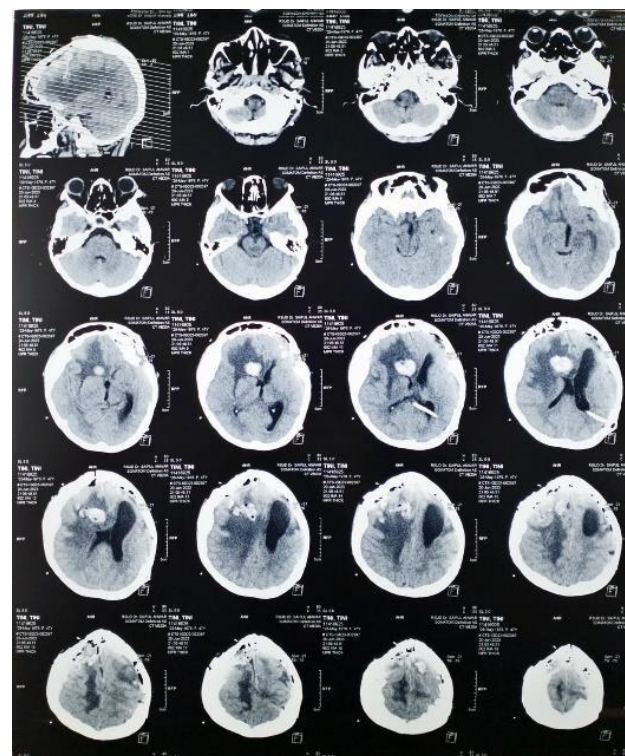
MRI examination 06/20/2023
